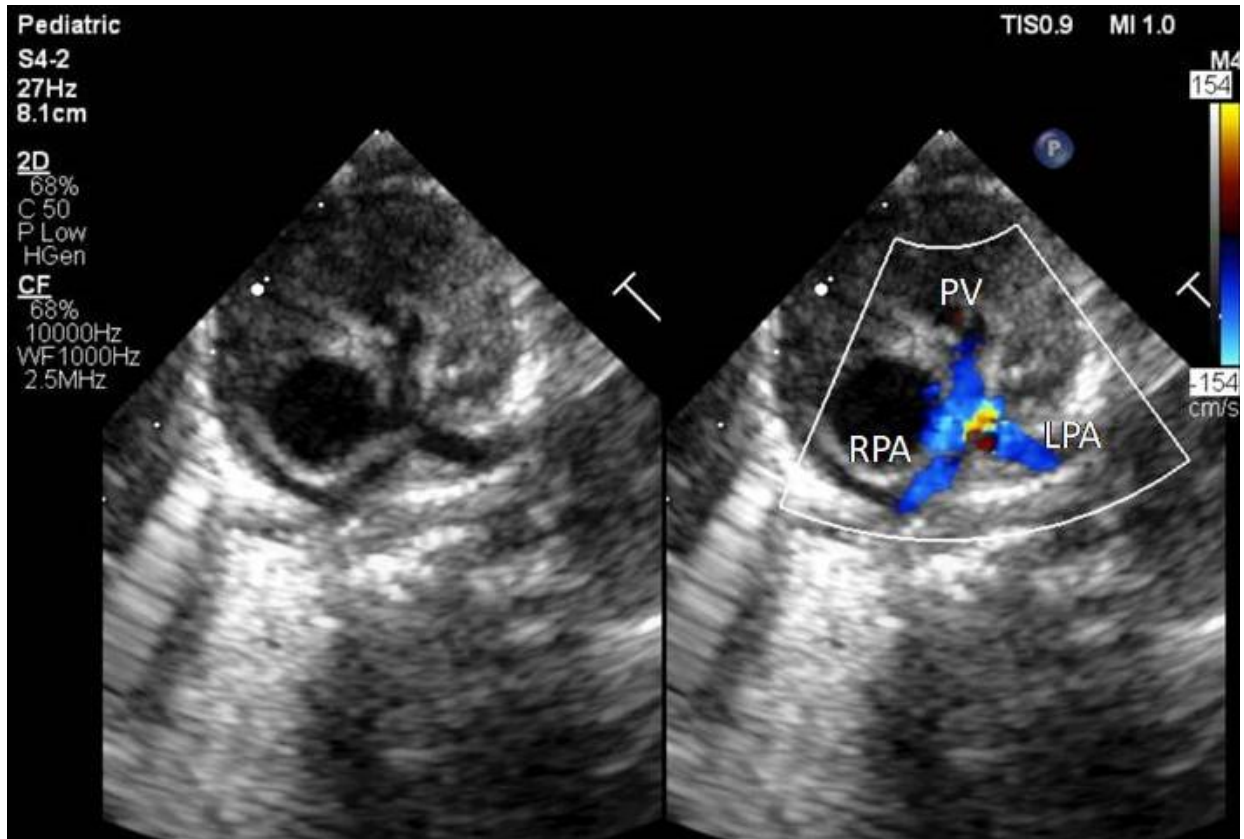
Echocardiography showing membranous pulmonary atresia with ventricular septal defect, confluent and good-sized branch PA's.
